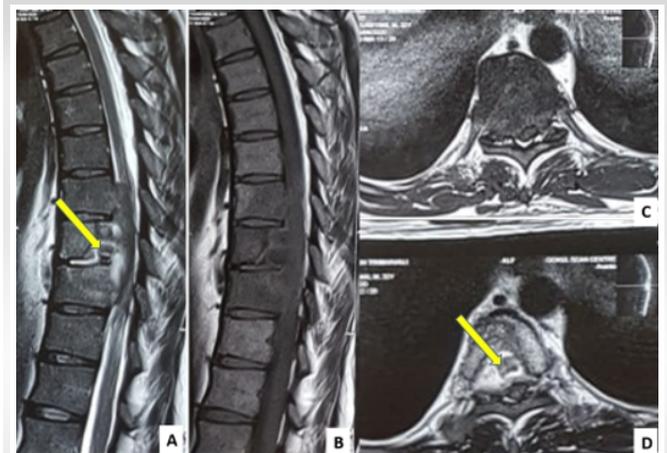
Shows MRI images of a 27 years old male patient who presented with worsening neurological deficit, progressing from Frankel D to Frankel B despite being on ATT. MRI images shows sequestered posterior vertebral body fragment retropulsed into the spinal canal
